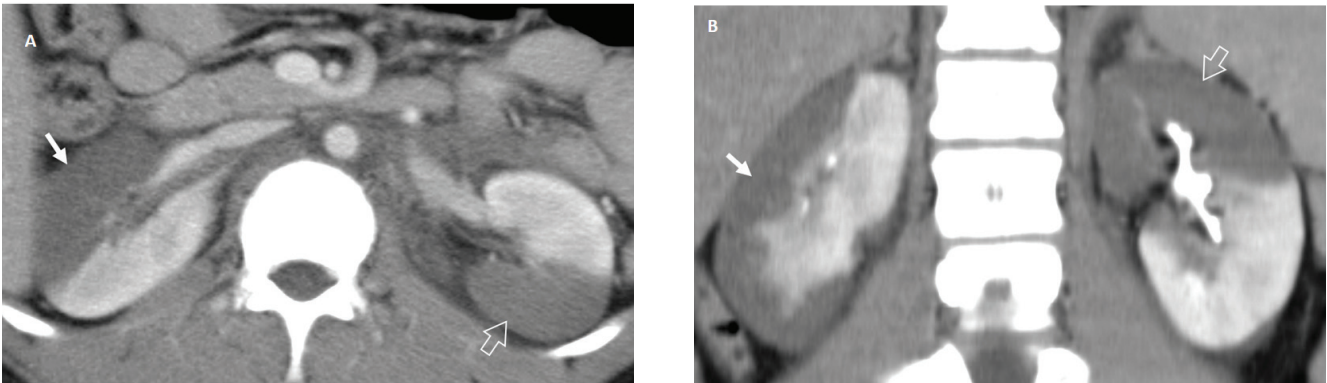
Segmental renal infarction of both kidneys. Enhanced CT scan in nephrographic phase in axial view (A) and excretory phase in coronal view (B) demonstrate the sharply defined area of unenhanced parenchyma of the anterior right renal (arrow) and posterior left renal parenchyma (blank arrow). Minimal retroperitoneal hematoma around the paraaortic region is noted.
